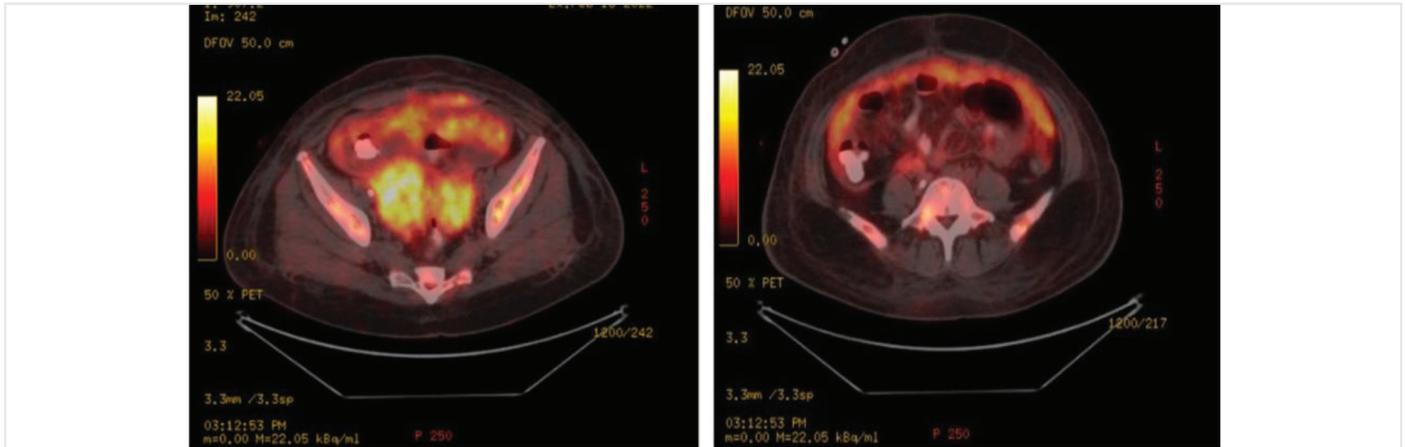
PET-CT images of bilateral ovaries and anterior abdomen-omentum
